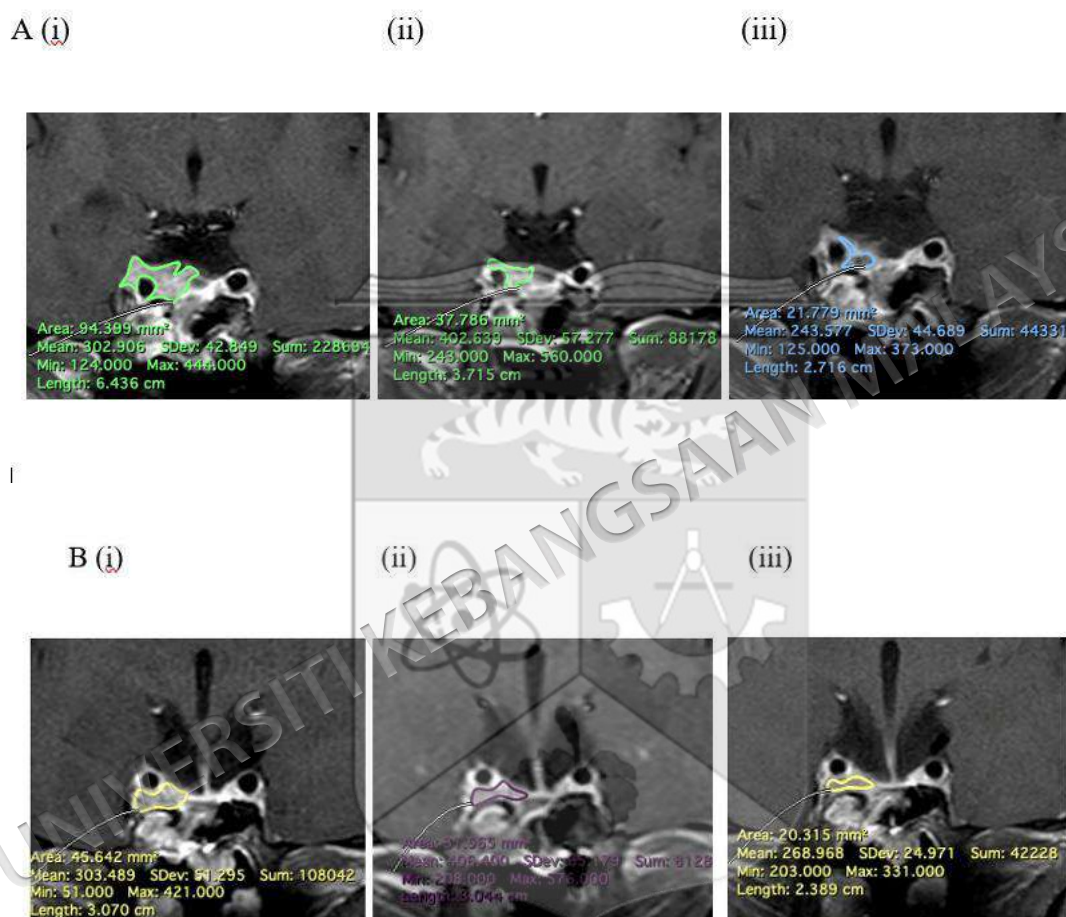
Representative MRI images of a patient who was treated with tamoxifen and whose tumour volume had shrunk the most
